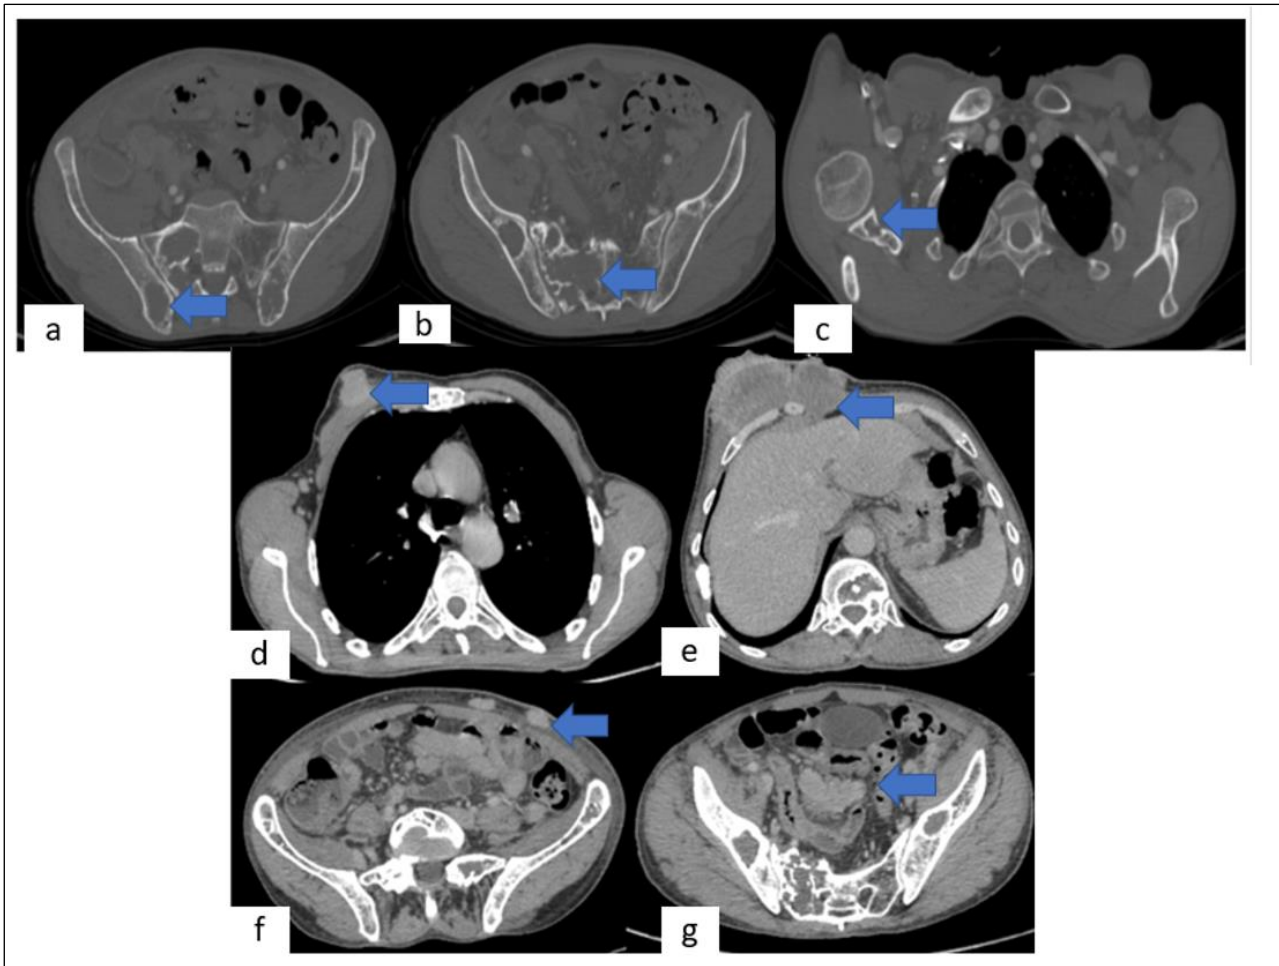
Thoraco-abdomino-pelvic CT shows the presence of masses and nodules in the parietal region in front of the right pectoral muscle and left axillary region, oval-shaped, well-circumscribed, heterogeneously enhanced after contrast injection (images d and e), multiple intra- and retroperitoneal soft tissue masses and nodules, oval-shaped, confluent in some cases, heterogeneously enhanced after contrast injection (image g), associated with multiple anterior abdominal wall soft tissue masses and nodules, oval-shaped, confluent in some cases, heterogeneously enhanced after contrast injection (images d and f). There are also multiple enhancing bone lesions involving the sternum, scapular girdle, ribs, and pelvic girdle, the largest of which involves the right sacral ala, invading the ipsilateral dorsal sacral foramina (images a, b and c), consistent with peritoneal, thoracic and abdominal wall secondary localizations and multiple axial bone lesions of the pelvic and scapular girdle in relation to multiple myeloma.
